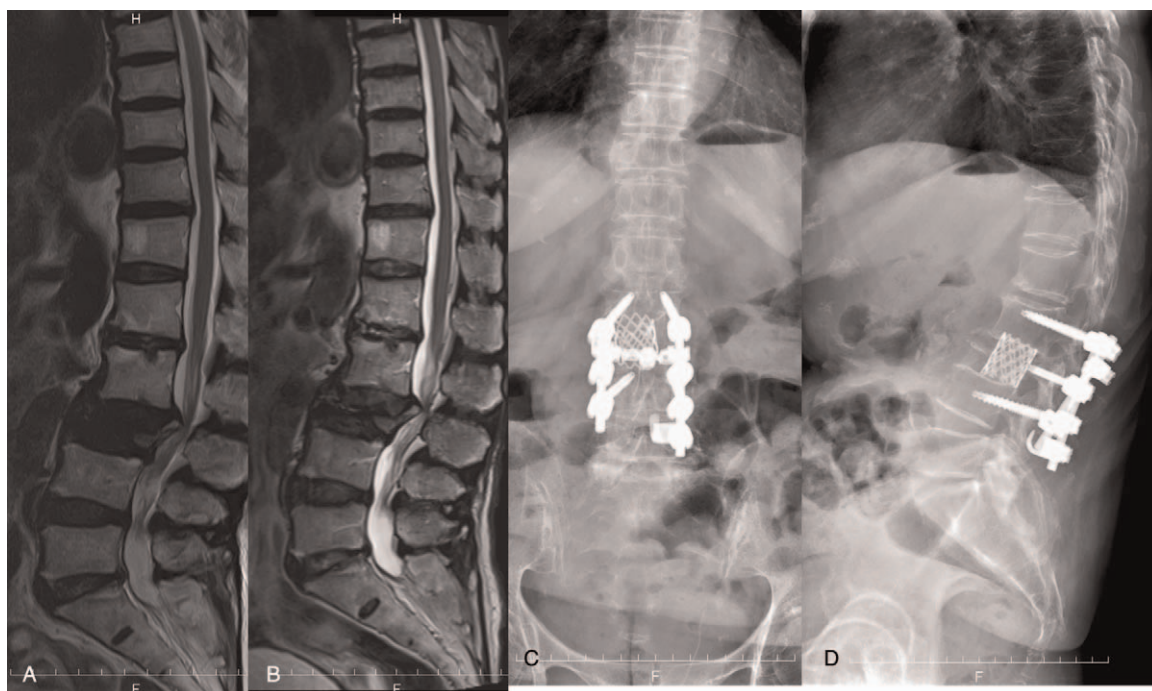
Mid-sagittal T2 magnetic resonance imaging at the baseline (A) and 3 months after the conservative therapy (B). The patient underwent the anterior-posterior decompression and fusion. Postoperative posteroanterior (C) and lateral (D) radiographs.
